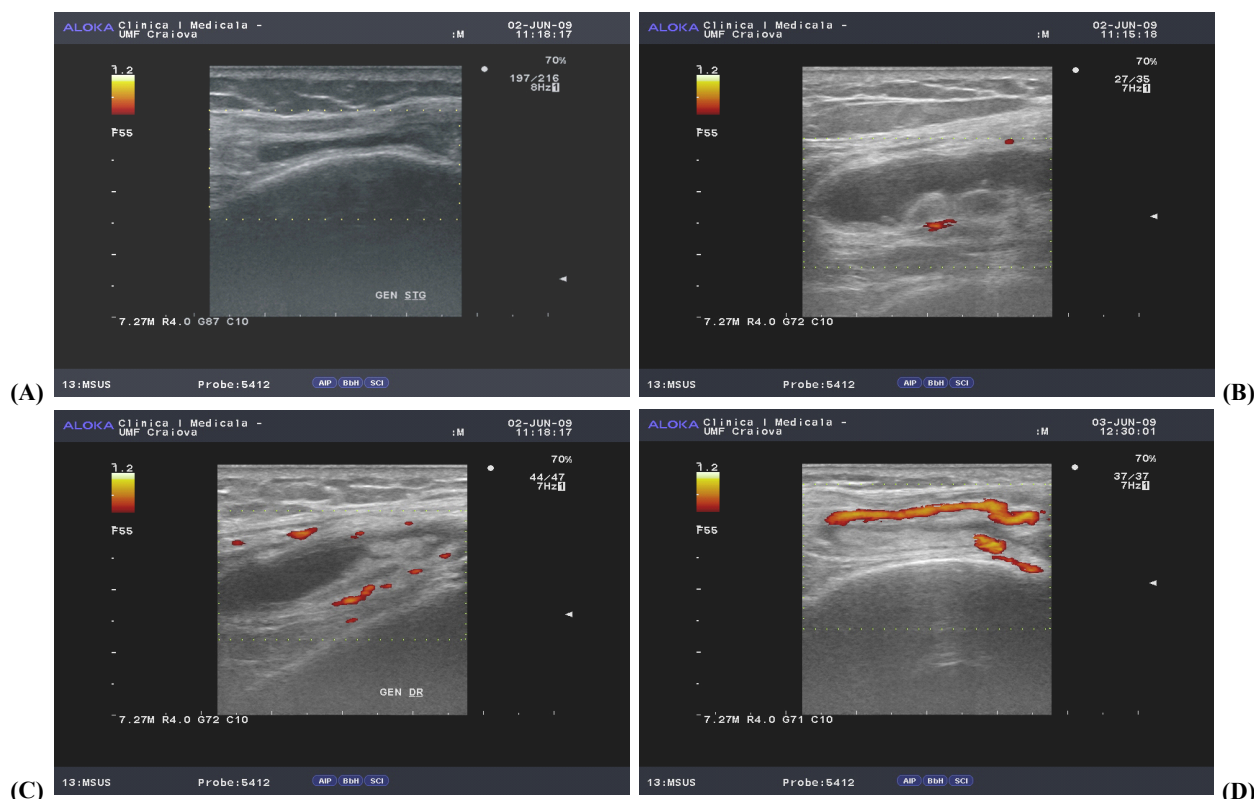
Representative power Doppler sonography (PDS) images obtained on the scan of the dominant knee: (A) Absence of PD signal (PDS score 0); (B) Single vessel dots: mild hyperemia (PDS score 1); (C) Confluent vessel dots over less than half the area of synovium: moderate hyperemia (PDS score 2); (D) Confluent vessel dots over more than half the area of synovium: high hyperemia (PDS score 3).
